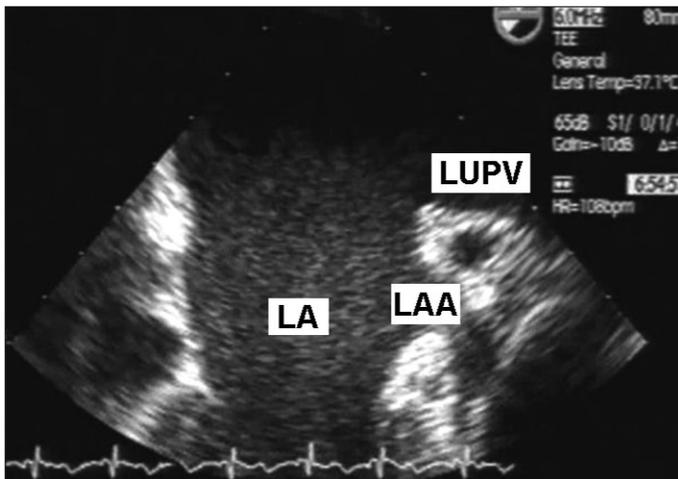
Transesophageal echocardiography after treatment with intravenous heparin showing complete resolution of left atrial thrombi
